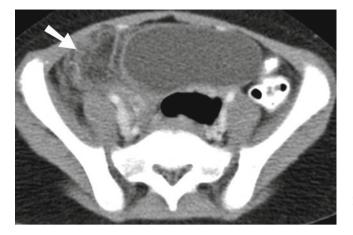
Acute segmental omental infarction. Contrast-enhanced CT in a child shows inflammatory omental lesion (*arrow*) in the right lower quadrant. The appendix was normal and seen at a higher level
